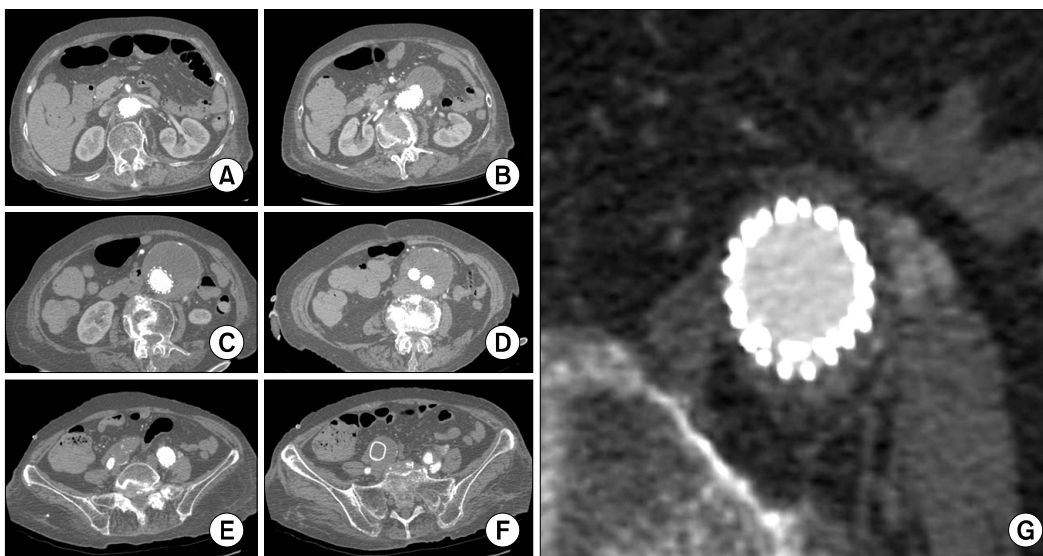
There was no endoleak found in aortic neck (A, B), aneurysm (C, D) and iliac arteries (E, F) on computed tomography scan in 1 month after endovascular aneurysm repair. Left common iliac artery was sealed by endograft and Palmaz XL stent (E). Right internal iliac artery was occluded by Amplatzer vascular plug (F). Endograft and Palmaz XL stent in left common iliac artery were magnified (G).
